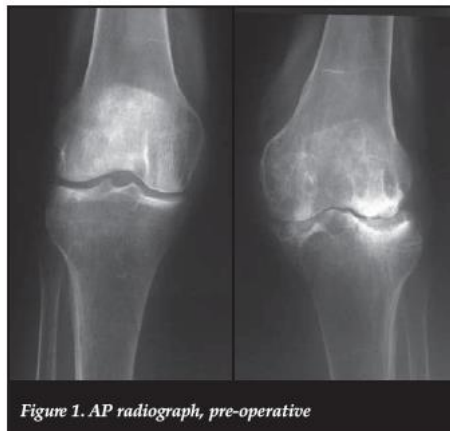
AP radiograph, pre-operative
